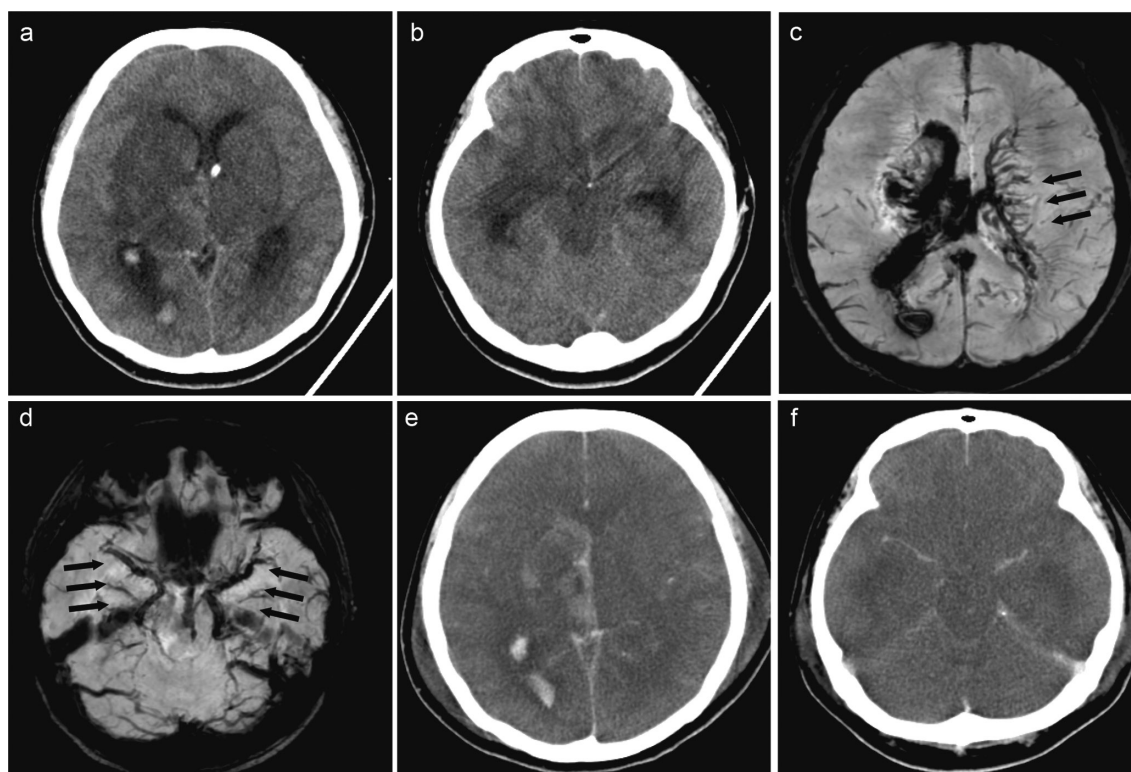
Computed tomography (CT) and magnetic resonance imaging of the head on the second day, and autopsy imaging. (a, b) CT of the head on the second day of hospitalization shows worsened brain edema and acute hydrocephalus. (c, d) Susceptibility-weighted magnetic resonance imaging on the second day reveals occluded deep cerebral veins with low intensity (arrows). (e, f) CT of the head (autopsy imaging) reveals whole-brain edema.
